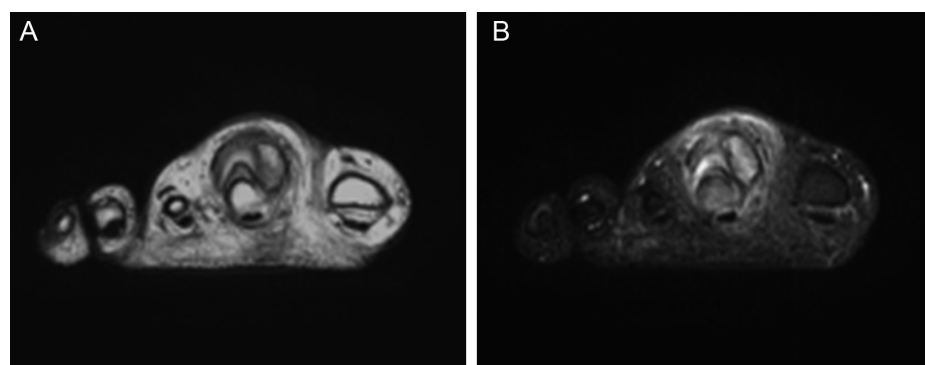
(A, B) Axial MRI showing focal high intensity in the soft tissue surrounding the bony lesion on T2-weighted imaging (A) and short-tau inversion recovery sequence imaging (B), indicating the presence of severe inflammation.
